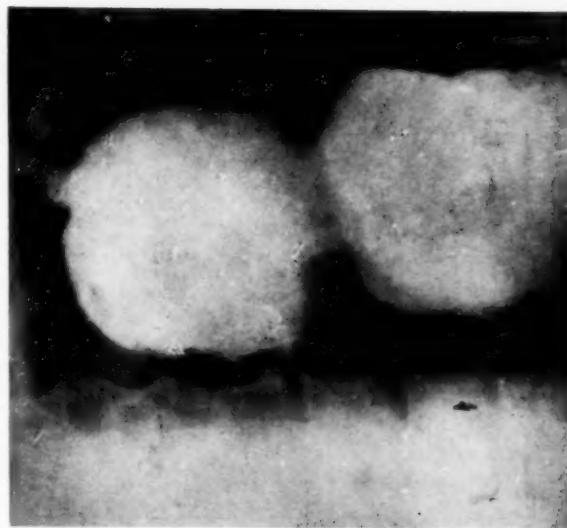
X-ray of stomach, after a large barium meal showing a marked constriction of the stomach due to the hernial orifice.
